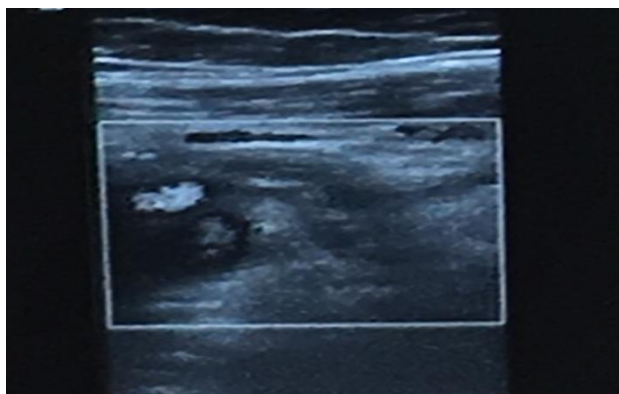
Preoperative pelvic ultrasonography which periappendiceal fat straining and free fluid, as well as enlargement of the appendiceal diameter.
